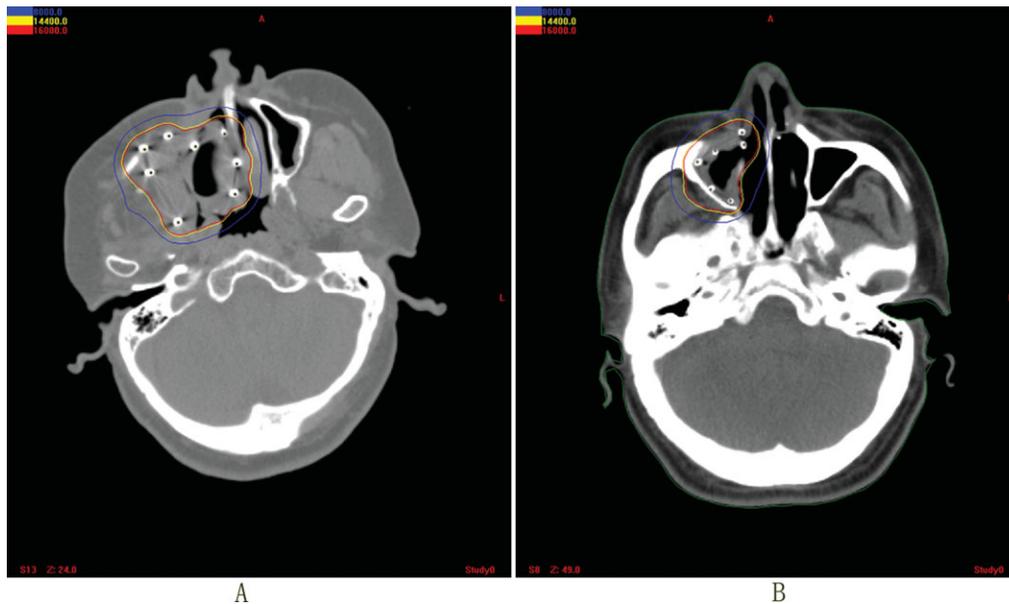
Computed tomography and brachytherapy treatment planning system analysis of radioactive seed and dose distribution with obturators. Radioactive seeds in obturators delivered doses to tissues of (A) nasal cavity and (B) residual maxillary sinus. The red line is the 100% dose isodose line (160 Gy), yellow is the 90% dose isodose line (144 Gy), and blue is the 50% dose isodose line (80 Gy).
